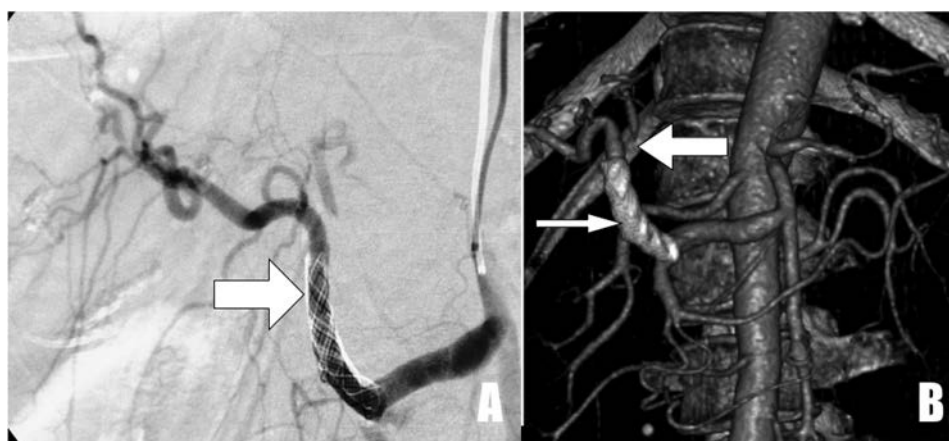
Visceral vessels angiography post stentgraft implantation to the common hepatic artery; B. CTA reconstruction: stentgraft in the common hepatic artery (small arrow), filling of the left hepatic artery (bigger arrow) despite stentgraft coverage
